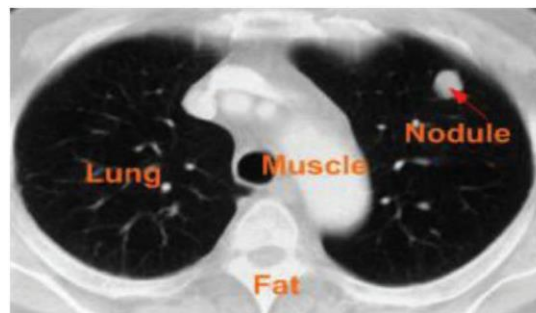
IMAGE OF THE AFFECTED PERSON WITH LC FROM CT SCANS
